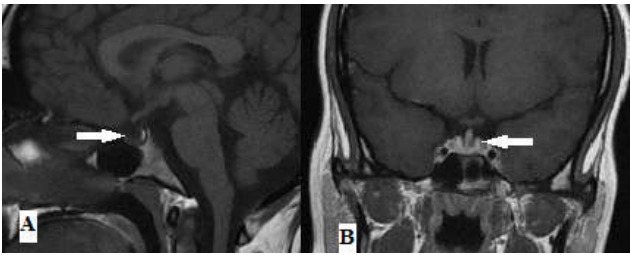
T1-weighted sagittal (A) and coronal (B) post gadolinium images reveal atrophy of the anterior pituitary gland (arrows) on follow-up MRI 5months later
